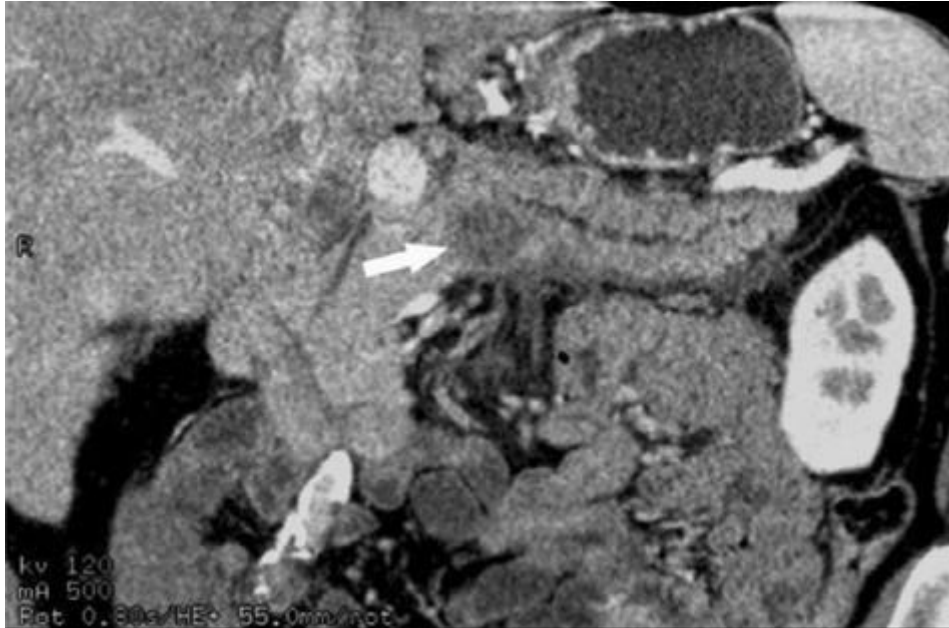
Curved planar reformatted CT image through the pancreatic duct shows the relationship of the tumor (arrow) to the pancreatic duct.
